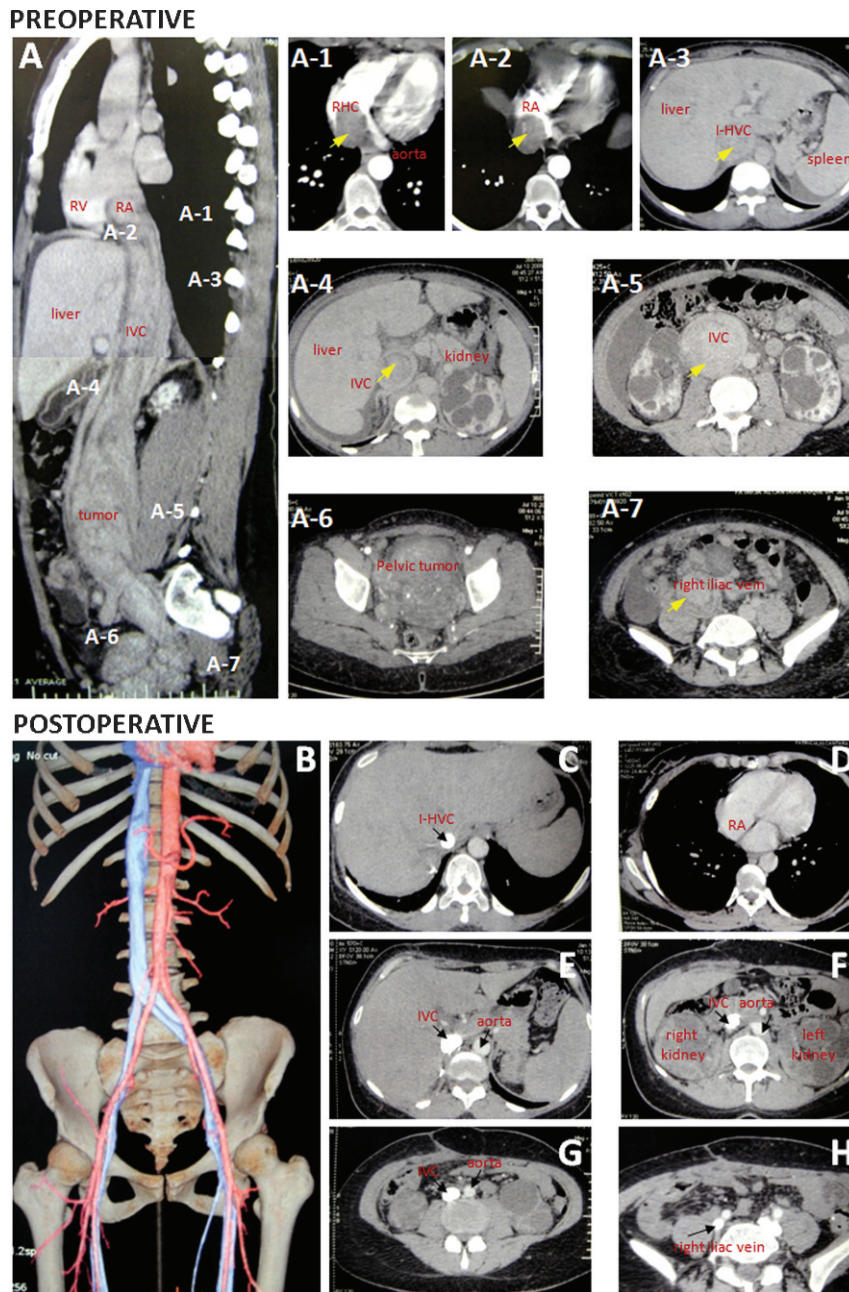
(A) A preoperative sagittal computed tomography (CT) scan showing a mass (leiomyoma) extending from the right internal iliac vein to the right atrium. Figures A-1 to A-7 show the transverse CT scans of the areas indicated in A. (A-1 and A-2) The intracardiac tumor. (A-3 to A-4) The intracaval tumor. Note that both kidneys presented with multiple cysts. (A-5) The severely dilated inferior vena cava (11 cm). (A-6) The multilobulated pelvic tumor with intense vascularization. (A-7) The intrailiac tumor. (B-H) The postoperative CT scans, showing absence of the tumor and a normal-diameter inferior vena cava. *I-HVC*, intrahepatic vena cava; *IVC*, inferior vena cava; *RA*, right atrium; *RHC*, right heart chambers; *RV*, right ventricle; *yellow arrow*, tumor localization; *black arrow*, vessel lumen.
